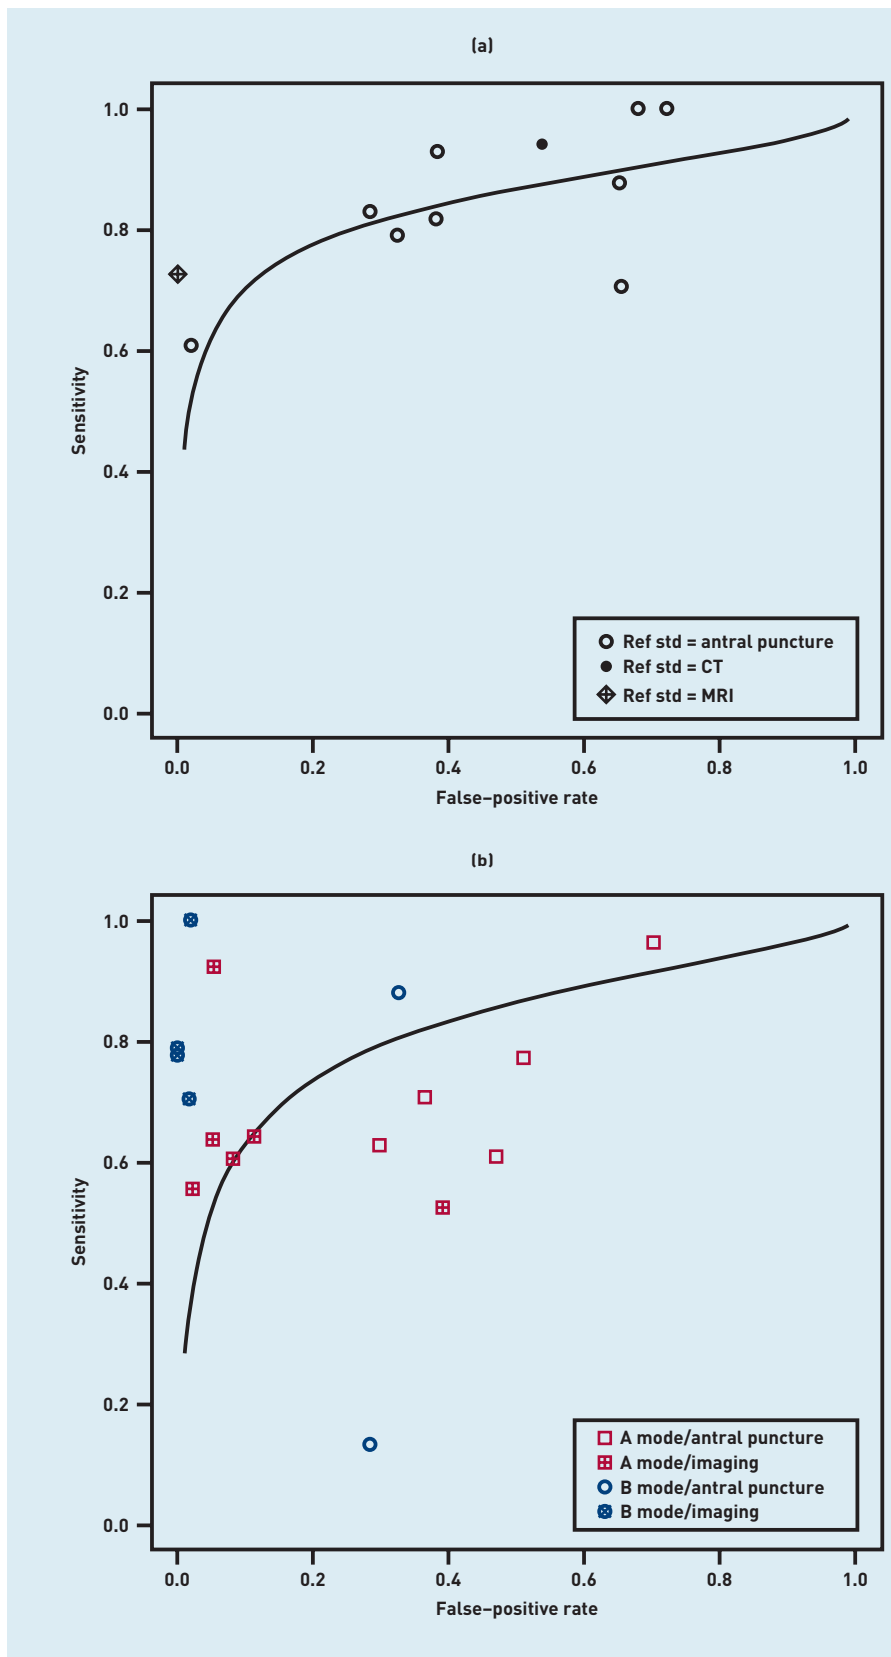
(a) Summary receiver operating characteristic curve for radiography, with accuracy stratified by the reference standard. (b) Summary receiver operating characteristic curve for ultrasound, with accuracy stratified by the reference standard for A and B mode. CT = computed tomography. MRI = magnetic resonance imaging. Ref std = reference standard.
